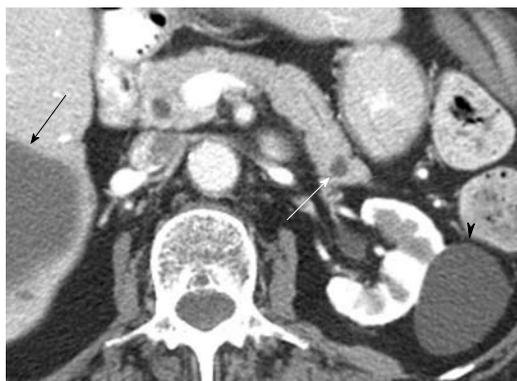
An 80-year-old woman with a history of hypertension, congestive heart failure and colon cancer. Axial contrast-enhanced computed tomography of the abdomen shows a small low attenuation lesion in the pancreatic tail consistent with a cyst (white arrow), a cyst within the kidney (arrowhead) and a cyst within the liver (black arrow).
